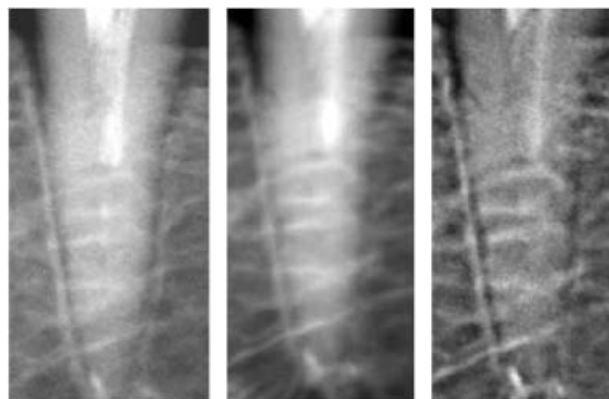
An oblique root fracture 2–3 mm below the marginal bone crest (left tooth surface) in a regular two-dimensional image (left) and in two versions of tuned-aperture computed tomography images (middle and right images). Courtesy of Dr Madhu Nair.
